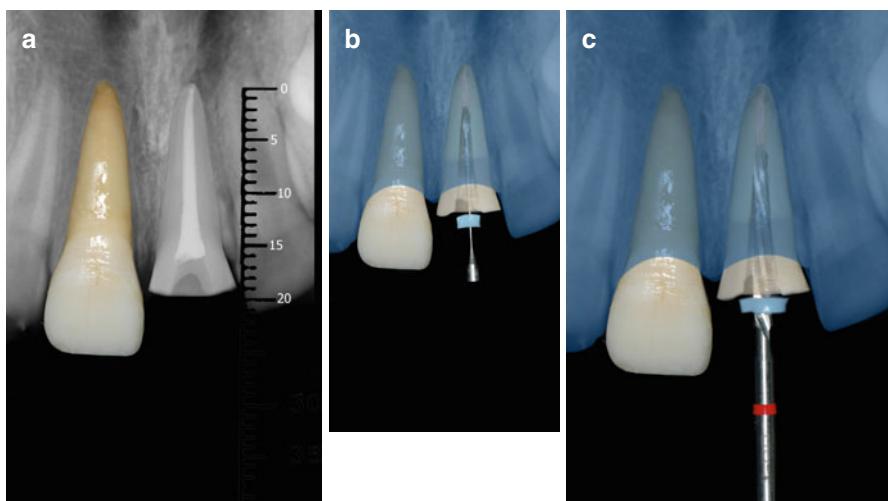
Initial preparation. In (a), a radiograph evaluation of the root canal length. In (b), removal of the gutta-percha with a Peeso reamer. (c) Use a carbide bur provided by the manufacturer of the fiberglass post for preparation of the root canal. After this step, a diamond bur with similar diameter can be used to produce a smear layer more susceptible to dissolution by phosphoric acid etching. This procedure is suggested for conventional resin cements and etch-and-rinse adhesives (Clinical case gently assigned by Prof. Leonardo Muniz; Muniz 2010; reprinted with permission)
